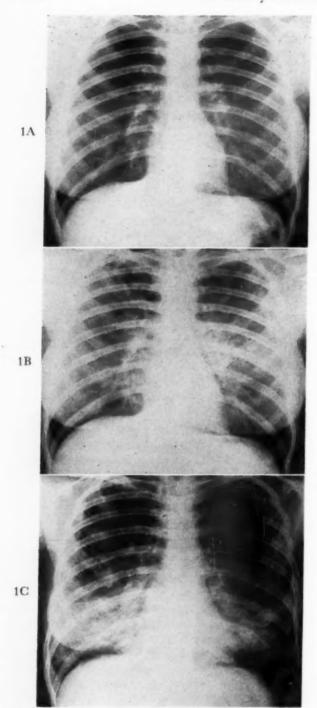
Case 1. A, roentgenogram of the chest taken on October 5, 1953. There is a patchy infiltrative type of lesion in the peripheral lung fields in each infraclavicular area at the first and second interspaces bilaterally. The changes appear fibrotic in nature. B, roentgenogram of the chest taken on January 2, 1956. A diffuse fine reticular type of lesion is distributed throughout the lungs on both sides, with a diffuse pneumonitis in the upper half of the right upper lobe. C, roentgenogram of the chest taken on July 12, 1958. A diffuse hard fibrosis extending from the apex to the diaphragm on both sides is suggested. In the basal regions this appears to have a somewhat nodular character.
